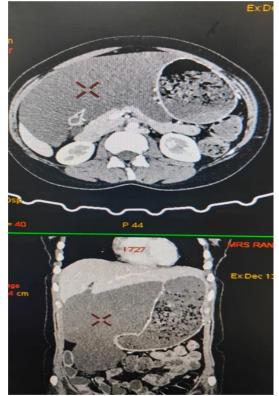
Coronal magnified image of contrast-enhanced CT (CECT) abdomen reveals a considerably large (25x18x10 cm, craniocaudal x transverse x anteroposterior) well-defined cystic lesion. The lesion extends from the subhepatic region to the hypogastric region, extending into the area of the Lesser sac and falciform ligament. It closely abuts the anterior margin of the pancreas. Numerous thin internal septations are observed within the lesion, suggesting a probable diagnosis of omental lymphangioma. Differential diagnosis includes the possibility of an encysted collection.
